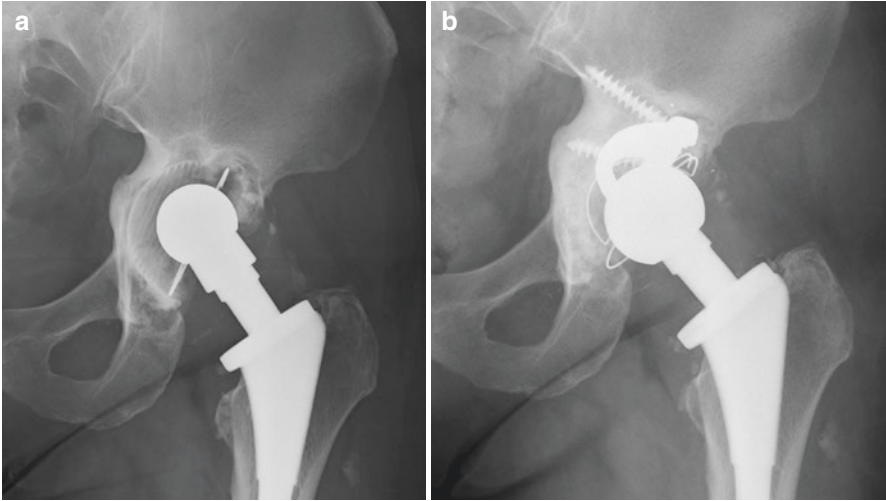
(a) Anteroposterior radiograph of a hip shows a failed impacting bone grafting of a revised cup. (b) A new impacting bone graft associated with tantalum augments were used in revision surgery
